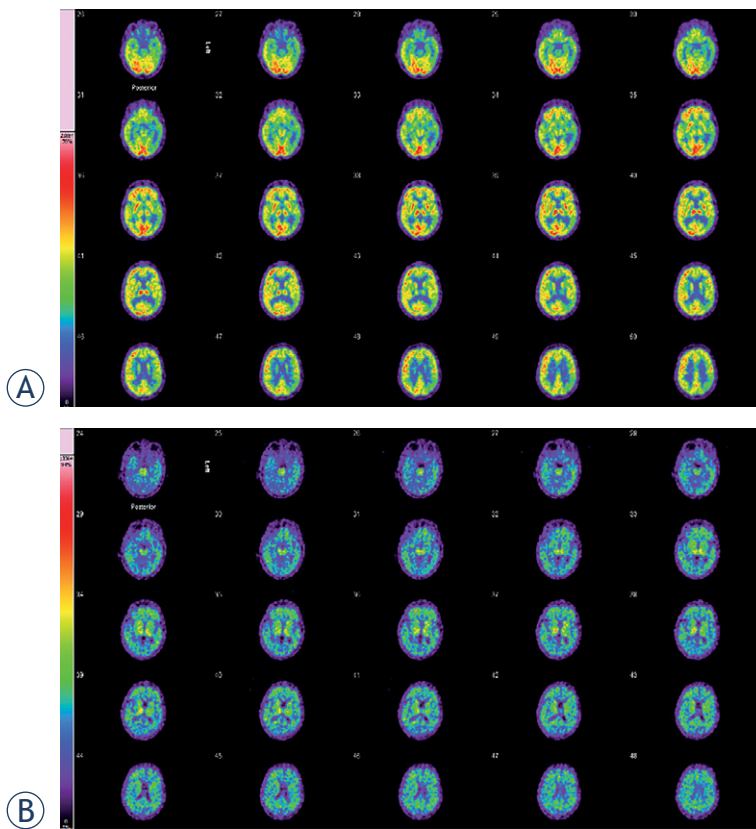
2-[18F] fluoro-2-deoxy-d-glucose (FDG) and amyloid brain PET/CT of 59-year-old woman. (A) FDG brain PET/CT of a 59-year-old woman with a history of fluctuating cognitive impairment (mini mental state examination [MMSE] = 14/30). Glucose hypometabolism was demonstrated in the parietal dorsolateral and temporolateral, and occipital cortical areas. The glucose metabolism in the left temporomesial area is weak. The other cortical structures show a slight attenuation of FDG metabolism. Basal ganglia show more intense uptake compared to the cortical areas. This FDG brain PET study shows the typical picture of abnormal glucose metabolism that occurs in Alzheimer's disease (AD) and is additionally compatible with pronounced microvascular changes. (B) On the amyloid PET a non-specific tracer accumulation from the pons to the basal ganglia is evident. PET images of the white matter demonstrate individual non-specific enrichments. In the frontal and temporal cortices as well as sporadically in the parietal cortical areas, a pathological tracer accumulation occurs. This global cortical tracer uptake is consistent with the neuropathology of AD.
